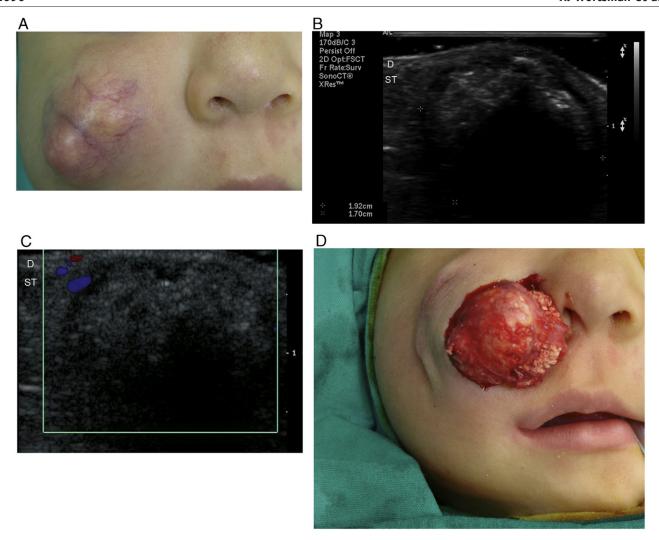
Case 2. A, Mass in the right cheek. B, Ultrasound (transverse view): hyperechoic round solid lesion occupying the deeper dermis and subcutaneous tissue with hyperechoic dots suggestive of calcium deposits. C, Color Doppler ultrasound (transverse view): increased blood flow around the nodule. D, The tumor at surgery. D indicates dermis; ST, subcutaneous tissue.
